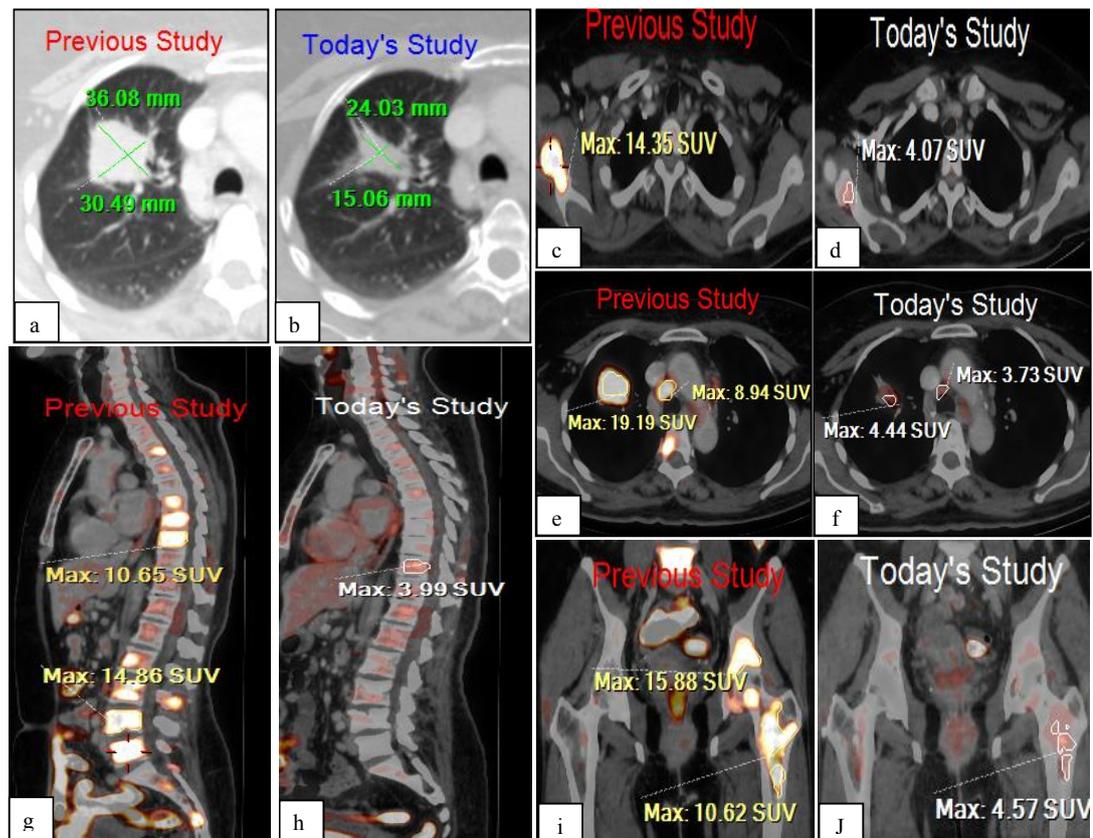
Follow up of 66 years old female patient has metastatic right upper lung lobe cancer and received chemotherapy; revealed good therapeutic response in the form of marked regression as the following; (a & b) axial CT images of the lung window show morphological reduction of the primary lesion size measuring 24X15mm compared to 36X30mm (previously), (c & d) axial CT images show significant reduction of the right hypermetabolic glenoid osseous lesion measuring (SUV max 4.07 compared to 14.3), (e & f) axial combined PET/CT images show metabolically reduced of the previously noted right lung lesion and retro-caval lymph node, achieving SUVmax 4.4 and 3.7 (compared to SUVmax 19.19 and 8.94 previously) respectively, (g & h) sagittal PET/CT images show almost no metabolically uptake of vertebral osseous lesions in recent image (previously 14.8 SUVmax) apart from faint metabolic uptake at D10 vertebral body (SUVmax 3.9 compared to 10.6) and (i & j) coronal PET/CT images show faint metabolically uptake of the left sub-trochanteric osseous lesion in recent image (SUVmax 4.5 compared to 10.6).
